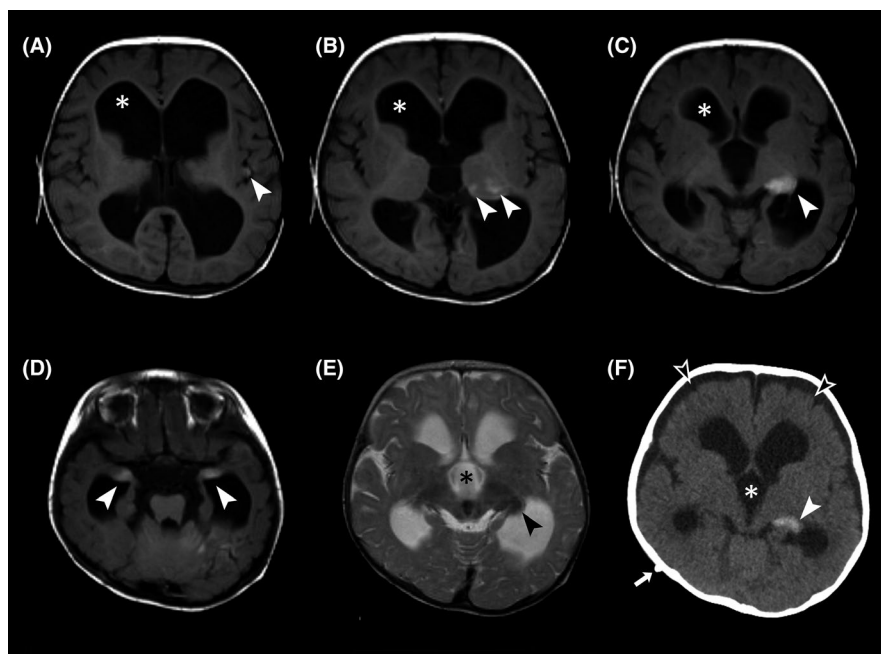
MR and CT scan of our 10-month-old patient with Neurocutaneous Melanosis and hydrocephalus. Axial T1-weighted images (A-D) MRI show a 10-month-old girl patient with hydrocephalus (white asterisk) and accumulation of melanin that presents with hyperintense signal (white arrowheads) in the insula (A), in the thalamus (B), in the retro-thalamic cistern (C), and in the amygdala bilaterally (D). Axial T2-weighted image of the same MRI acquisition (E) shows hypointense signal of melanin accumulation in the thalamic region (black arrow head) and hydrocephalus (black asterisk). After ventriculoperitoneal shunt placement (white arrow), axial CT scan (F) shows decrement of hydrocephalus (white asterisk), hyperdensity of the retro-thalamic cistern (white arrow head), and bilaterally frontal hygroma (black arrow head)
